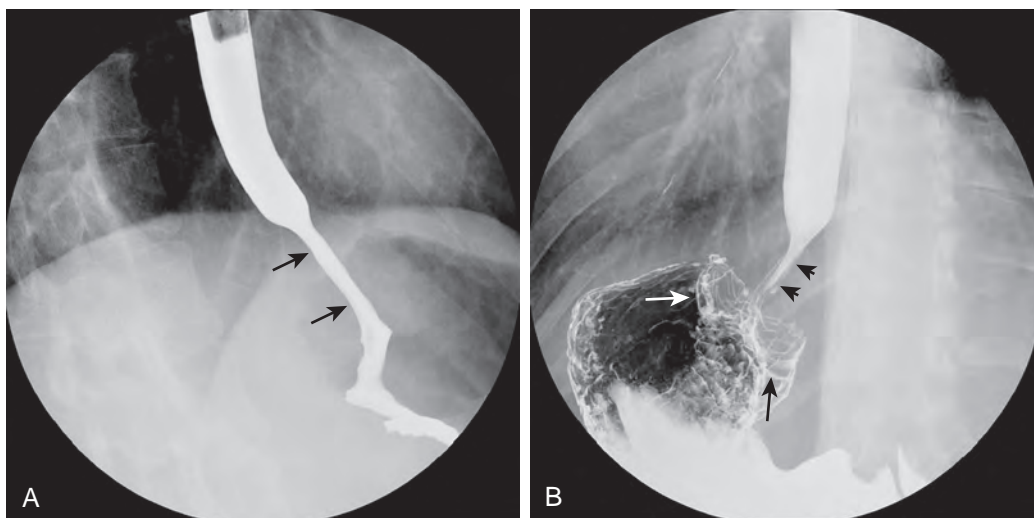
Persistent obstruction by a tight Nissen fundoplication wrap. A. Spot radiograph obtained with patient in an erect position shows that the lumen of the stomach is mildly narrowed (measuring ≈ 6 mm in luminal diameter; arrows) by a tight fundoplication wrap (arrows). B. Spot radiograph obtained while the patient is drinking in a right anterior oblique position shows a narrowed distal esophagus (thin arrows) and large fundoplication wrap (arrowheads).
